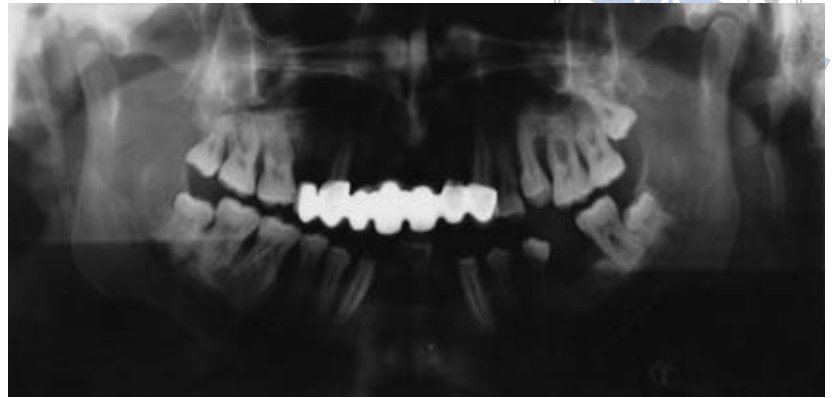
Case A: panoramic radiograph of the situation in 2000, showing furcation involvement in most of the molars, and a generalised pattern of advanced bone loss.
